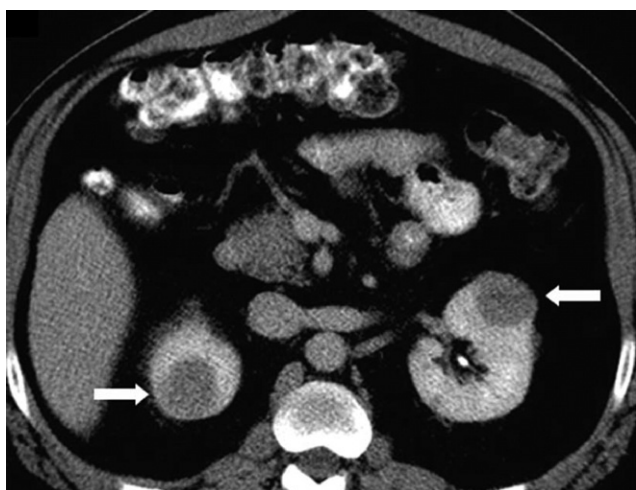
Hereditary papillary RCC syndrome. Axial contrast-enhanced CT in the nephrographic phase shows bilateral, uniformly low-attenuating papillary RCCs (arrows) in a patient with HPRC syndrome.
